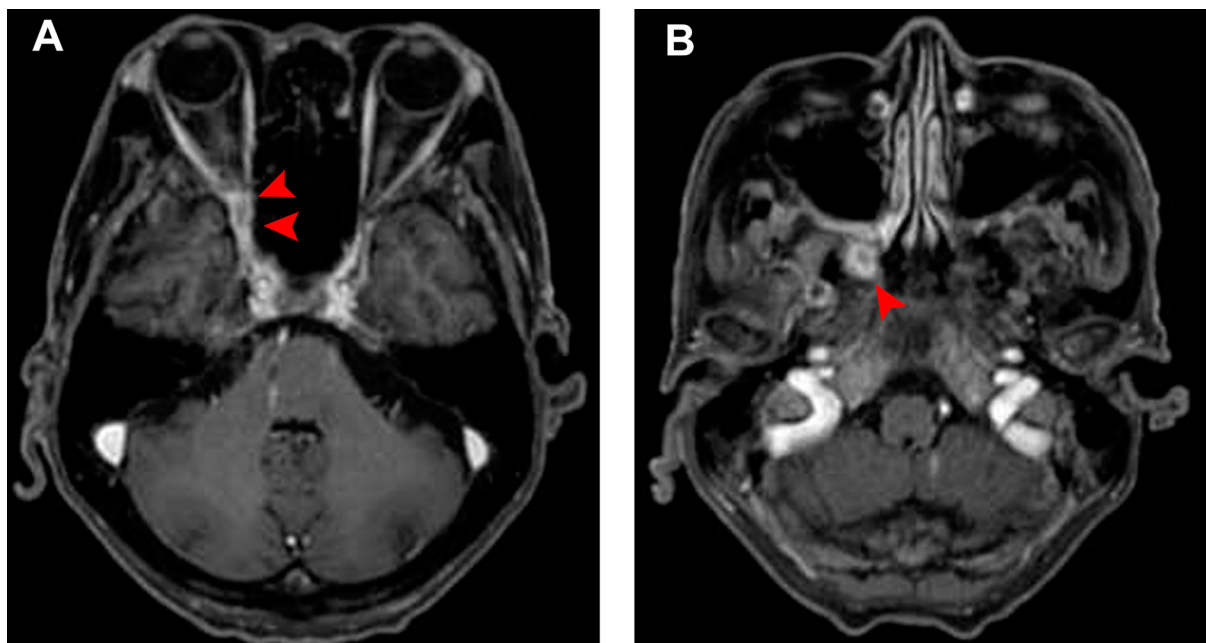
Fat-suppressed T1-weighted magnetic resonance imaging of the orbit. Abnormal soft tissue lesions showing high signal intensity (red arrows) are observed at the right (A) orbital apex and (B) inferior orbital fissure.
